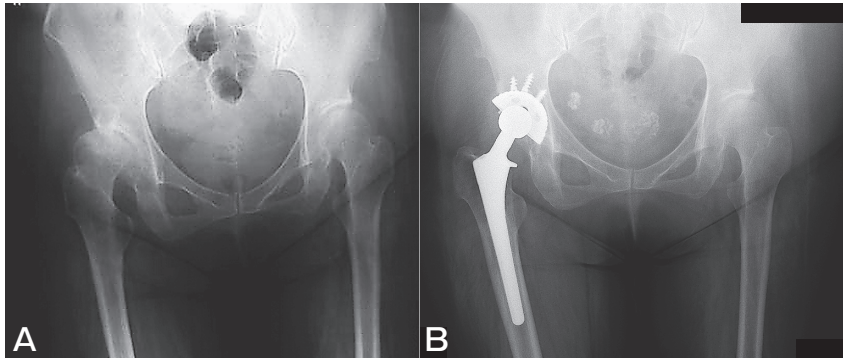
Representative paralytic-side THA case (Patient 2). A, Preoperative AP radiograph; B, Postoperative (10 years) AP radiograph.
